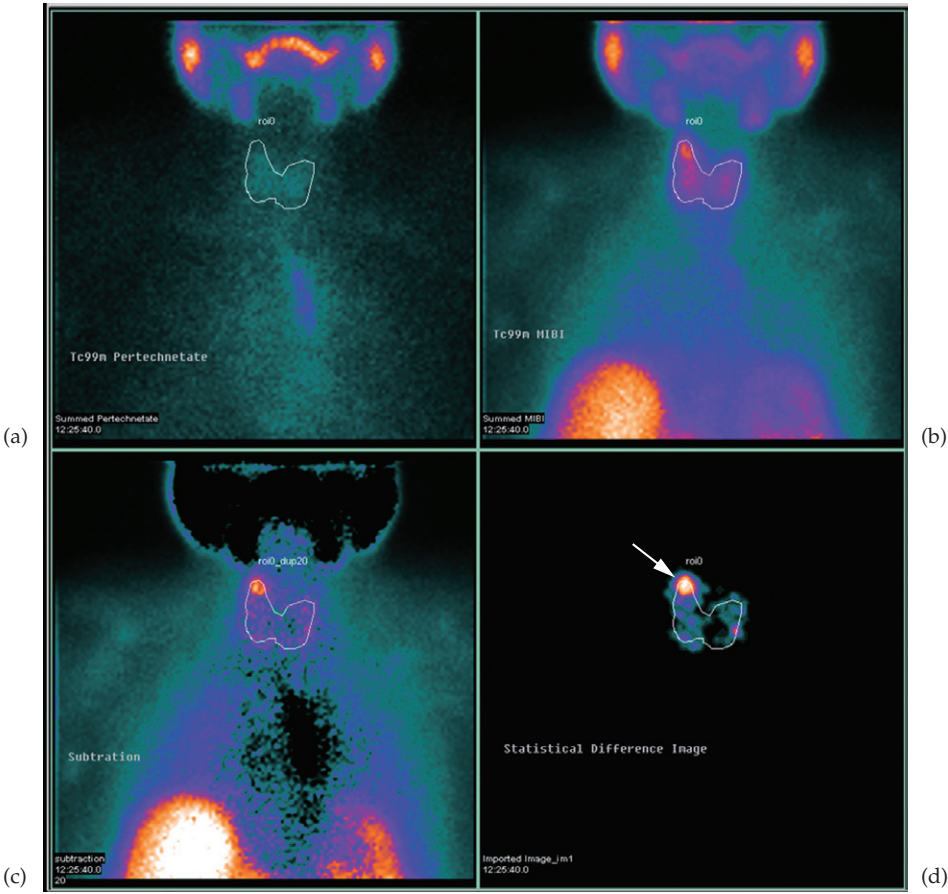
Subtraction scintigraphy showing a single right upper pole adenoma (arrow). (a) ^{99m}Tc Pertechnetate acquisition. (b) ^{99m}Tc Sestimibi acquisition. (c) Subtraction image. (d) Statistical difference image.
